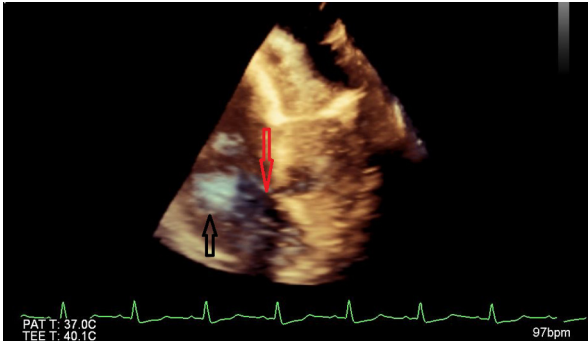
3D echocardiogram showing ventricular septal defect (red arrow) and necrosis (black arrow).
